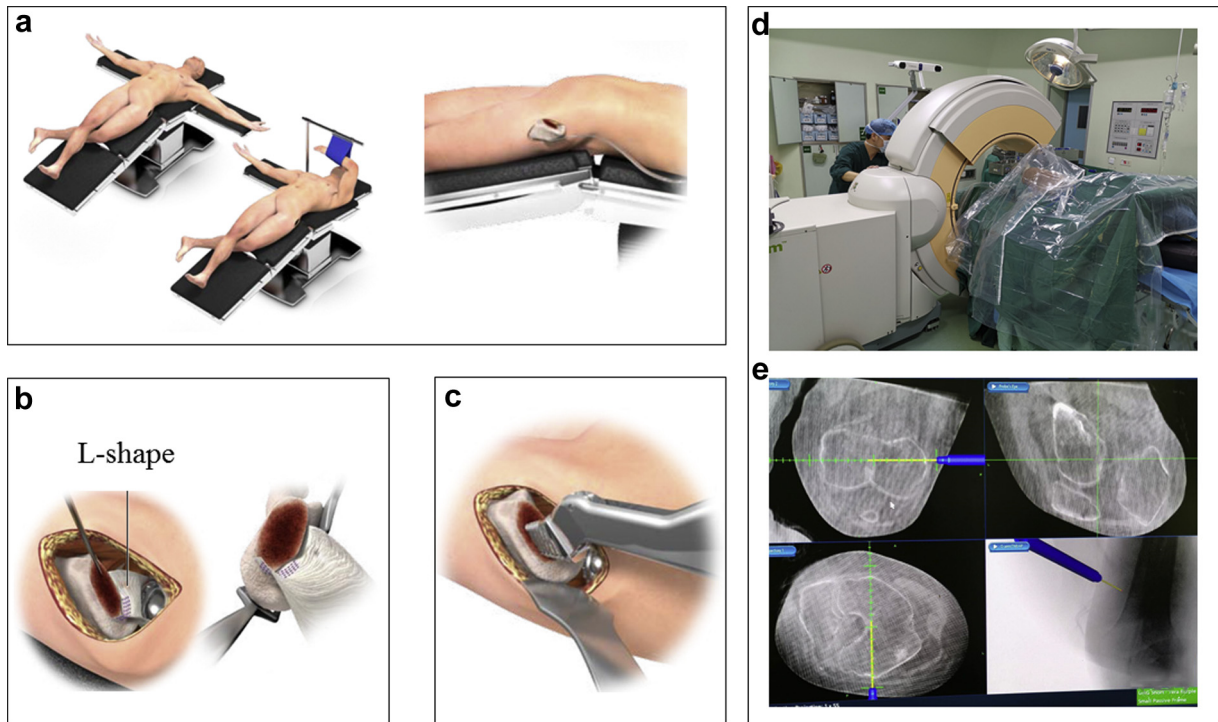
(a) Femoral broaching and reaming can only be initiated when adequate exposure of the proximal femur is achieved. (b) Femoral release of the superomedial capsule attachment at the base of the great trochanter using a reverse “L” manner until the internal side of the great trochanter is visualized. (c) Adequate release is achieved by moving the broach straight into the femoral canal without any obstruction from the iliac crest. (d) Intraoperative CT scanning and navigation to determine the degree of femoral anteversion. (e) The transepicondylar axis of the femoral condyle is used as a reference, and the femoral anteversion is set to be 10°–15°.
